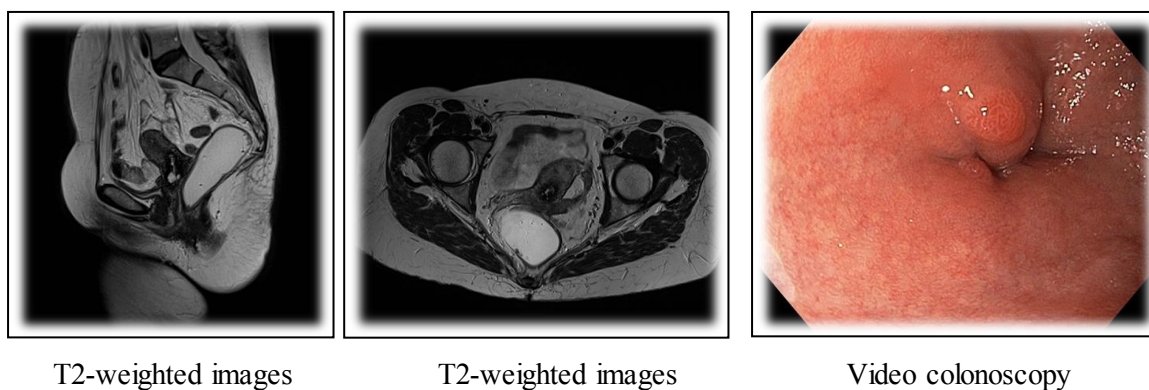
T2-weighted images of a rectal polyp in case of retrograde filling with a gel. Video colonoscopy of the same patient.
